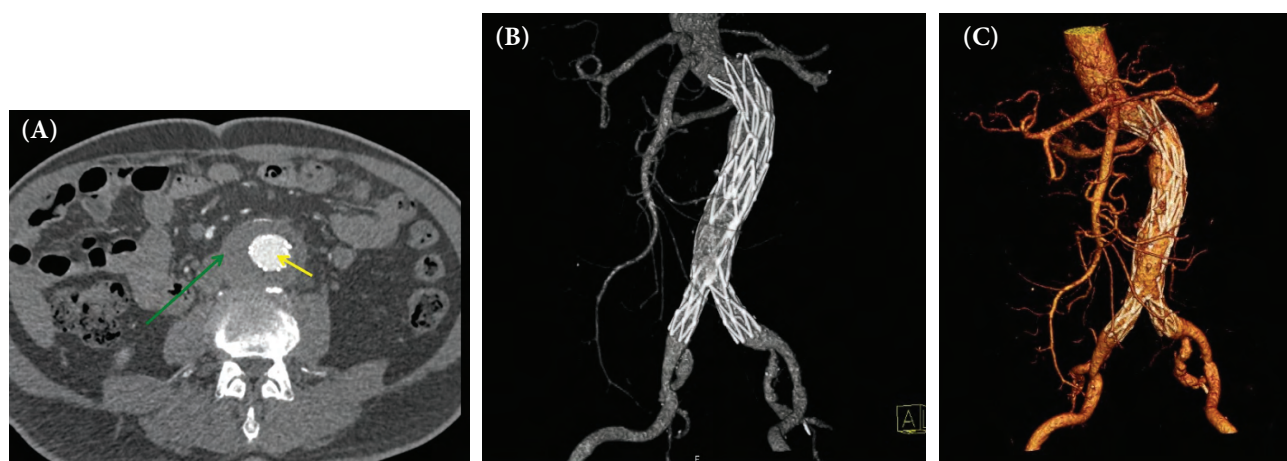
CT images of the same patient 6 months postoperatively: contrast-filled lumen (yellow arrow) and the thrombosed aneurysm (green arrow) on an axial CT image (A); bifurcated stent graft VRT image (B and C).
